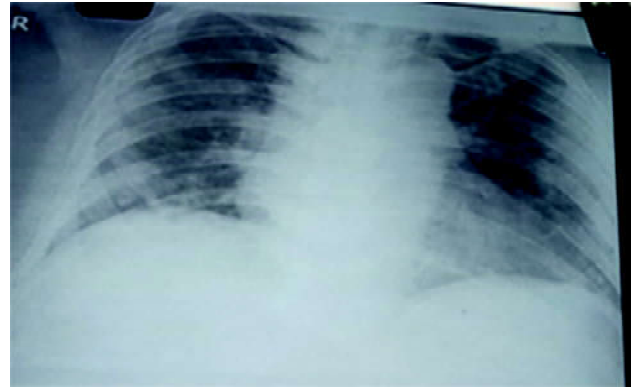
Chest X-ray showing bilateral peripheral consolidation (Case 4) before plasma therapy.
